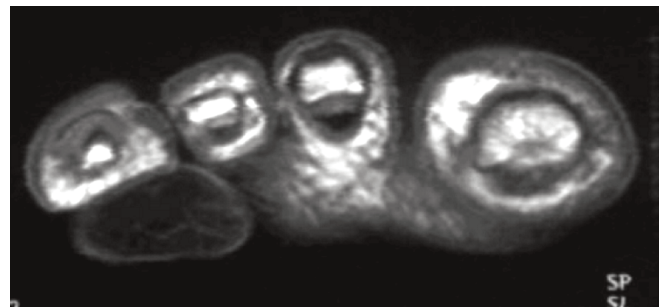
T1-weighted image of the same dermatofibroma shown in Figure 13 demonstrating an intermediate signal intensity.
